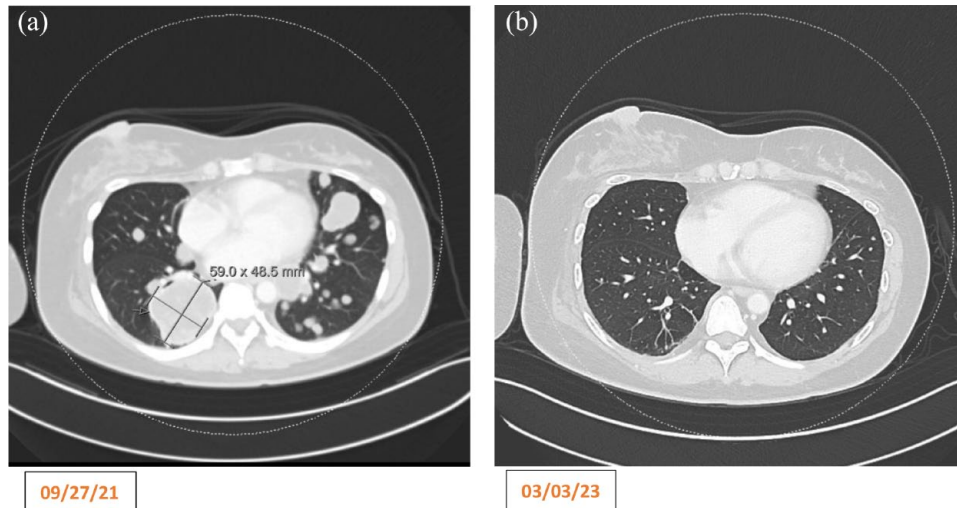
CT imaging of pulmonary metastases before immunotherapy (a) and after cycle 24 of pembrolizumab (b).
